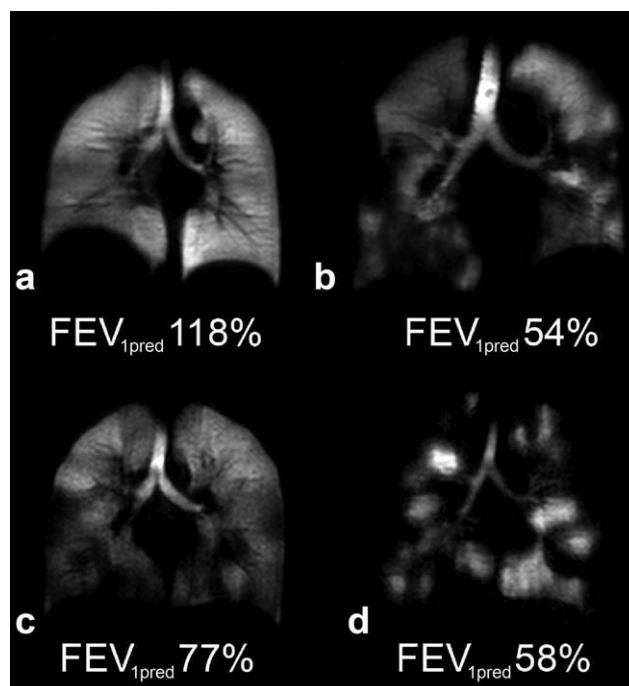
HP He MRI static ventilation center coronal slice images. a: Healthy volunteer, 45-year-old female with FEV_1 predicted = 118%. b: COPD, 79-year-old male with FEV_1 predicted = 54%. c: Asthma subject at baseline without provocation, 26-year-old male with FEV_1 predicted = 77%. d: Cystic fibrosis, 23-year-old female with FEV_1 predicted = 58%.
